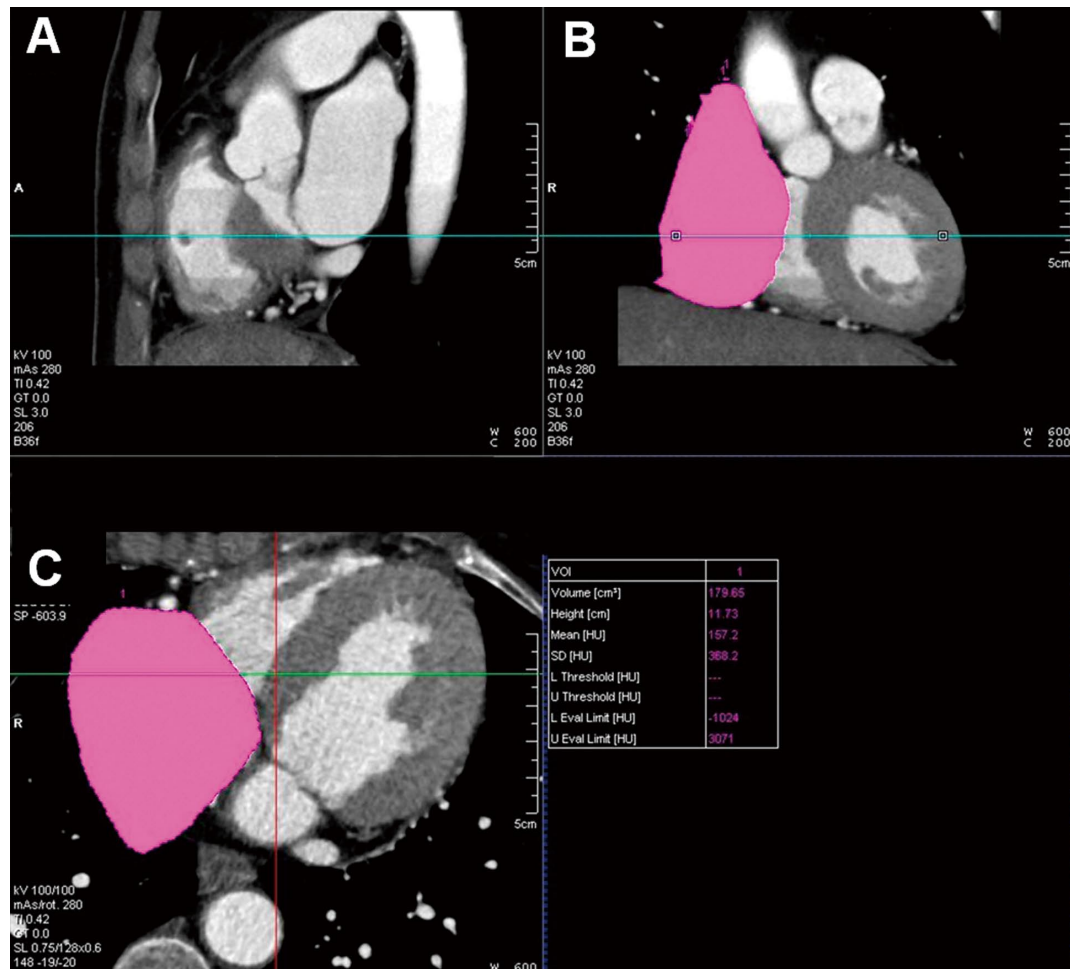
Three-dimensional measurement of the right atrial (RA) volume using multidetector computed tomographic images. (A) Coronal view of the heart showing the RA. (B) The margin of the RA was automatically traced using a commercially available workstation (Syngo, Siemens, Germany). (C) Sagittal view of the heart showing the RA and the margin of the RA was automatically traced.
